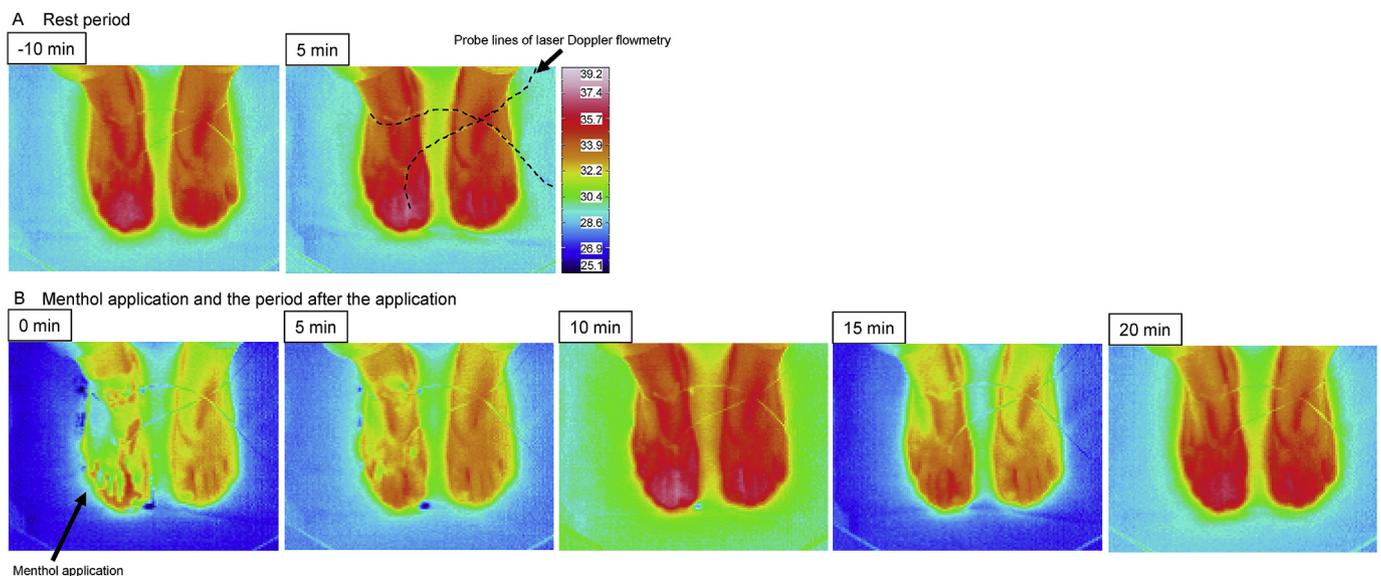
Typical thermograms of the feet. The thermograms were obtained from one subject in the P phase during the rest period (A) and during menthol application and the period after the application (B). The hashed lines indicate the probe lines for laser Doppler flowmetry.
